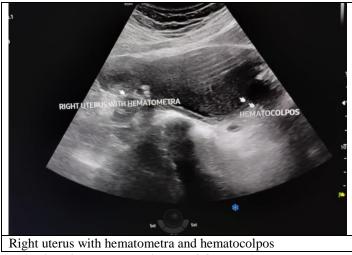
Ultrasound image of OHVIRA syndrome.
